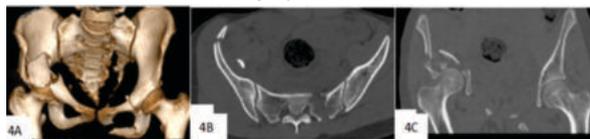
3D CT reconstruction shows a comminuted displaced fracture of the right acetabulum and iliac bone with protrusio acetabuli. Displaced fracture of left inferior ramus and sacrum on the left side is also seen.
